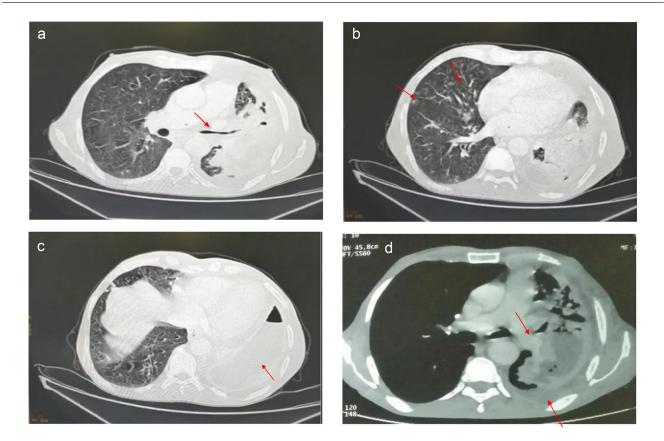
(A) Thoracic CT scan with axial parenchymal section in favor of a left pulmonary abscess communicating with the left lobar bronchus. (B) Thoracic CT scan with axial parenchymal section showing peribronchovascular and subpleural pulmonary nodules and micronodules in the right lobar. (C) Thoracic CT scan with axial parenchymal section showing a left pyo-pneumothorax (D): Chest CT scan with mediastinal sections: in favor of a left pulmonary abscess communicating with the left lobar bronchus, with a left pyo-pneumothorax appearing to communicate with the pulmonary abscess.
